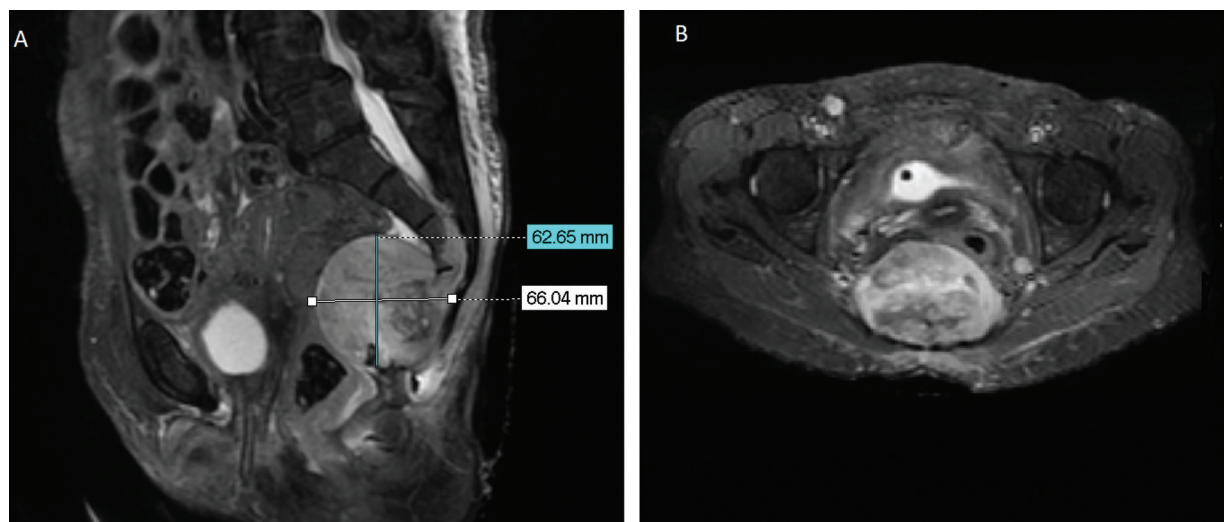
Magnetic resonance imaging scan in short tau inversion recovery (STIR) sequence showing a regular hypodense mass ventral to the sacrum (sacral chordoma), in (A) sagittal incidence and (B) axial incidence.
